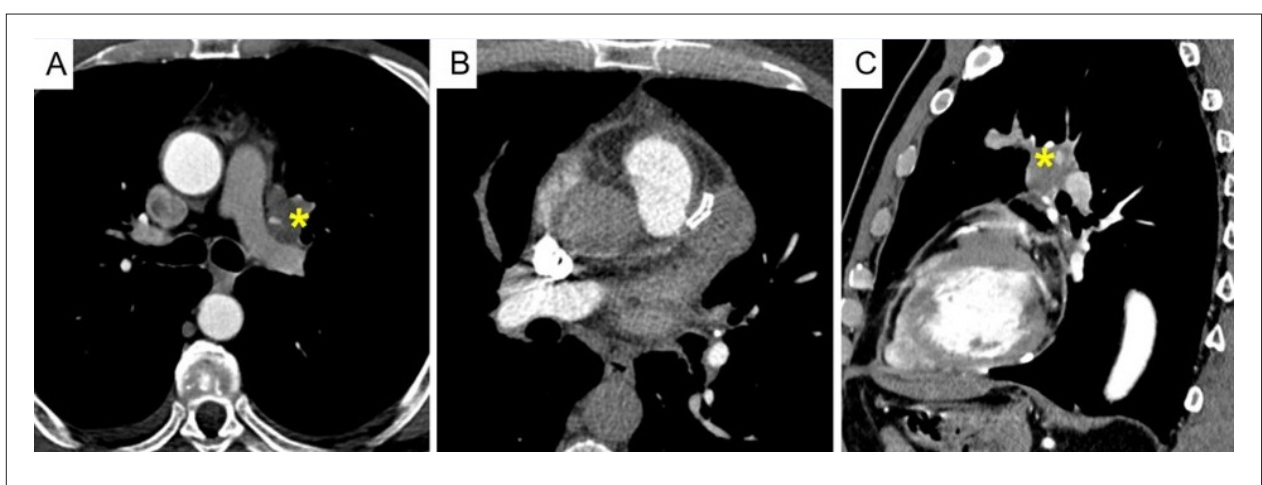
Thoracic CT (A) (C) Suspicious pulmonary lesion (*) in the left hilum, just next to the left superior lobe bronchus with invasion of the left superior pulmonary vein. (B) Metastatic mass in close contact with the LAD stent causing secondary involvement of the pericardium.
